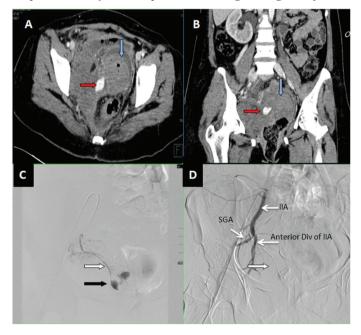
CT angiography images (A, B) showing pseudoaneurysm (red arrow) and surrounding hematoma (blue arrow) in the right lateral wall of the vagina. DSA spot images (C, D) of the same patient showing pseudoaneurysm (black arrow) arising from the right vaginal artery (white arrow), which was embolized with a 30% glue injection, and post embolization angiogram (D) showed non-filling of pseudoaneurysm suggestive of successful embolization
